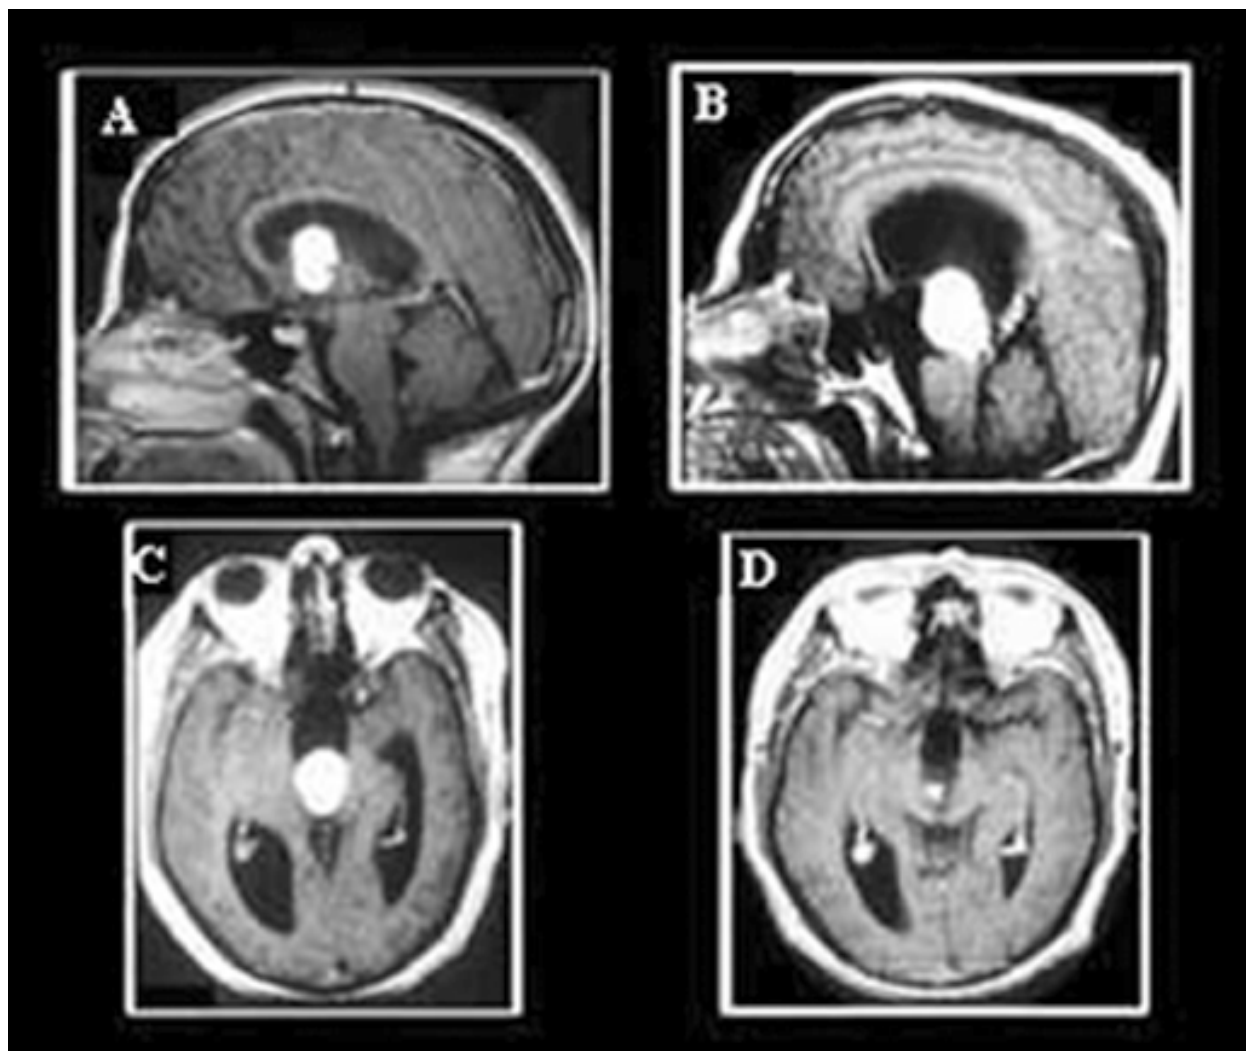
A, Preoperative midsagittal MR imaging brain showing colloid cyst within the anterior aspect of the third ventricle. B, Preoperative midsagittal MR imaging brain showing colloid cyst within the posterior aspect of the third ventricle. C, Preoperative axial MR imaging brain of the same patient with posteriorly located colloid cyst. D, Postoperative axial MR imaging brain with gadolinium performed 1 year after endoscopic removal of the colloid cyst. Improvement of hydrocephalus and remnant of the cyst wall are noted. [Reprinted with permission from El-Ghandour NM (2009). Endoscopic treatment of third ventricular colloid cysts: a review including ten personal cases. *Neurosurg Rev*, Vol. 32, No. 4, (October 2009), pp. 395-402, ISSN 0344-5607].
